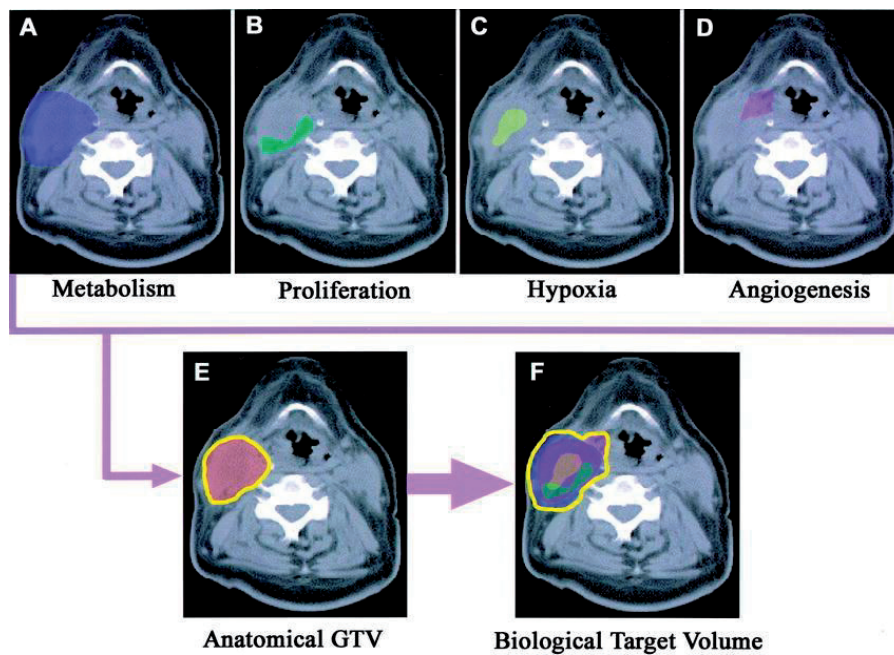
Imaging paradigm in radiation oncology integrating different functional imaging modalities (panel A-D) with CT defined GTV (panel E) to obtain a combined BTV (panel F).*⁷³
